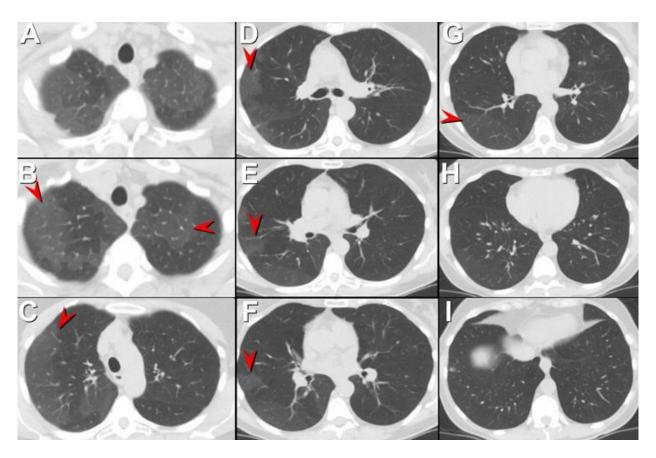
Repeat axial enhanced chest CT displayed in lung windows.
